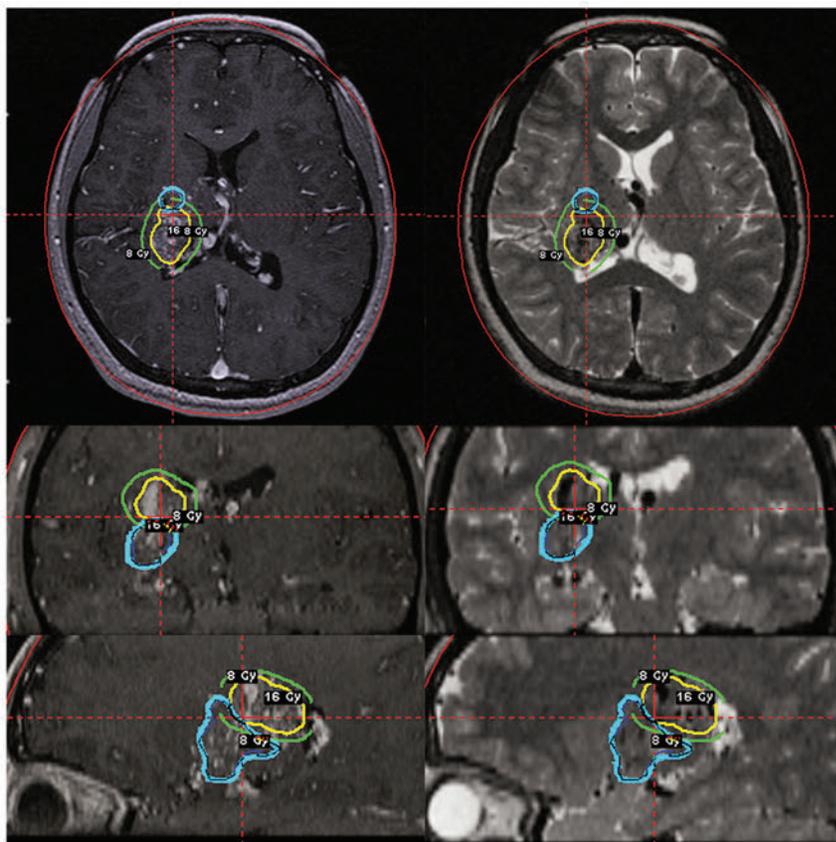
Volume-staged gamma knife radiosurgery plan (16 Gy to the 50% isodose line) for a 12-year-old girl with a thalamic arteriovenous malformation. Axial (upper), coronal (middle), and sagittal (lower) T1-weighted contrast-enhanced and T2-weighted magnetic resonance images showing an anatomical component of the first (blue line) and the second (yellow) volume-staged stereotactic radiosurgery.
